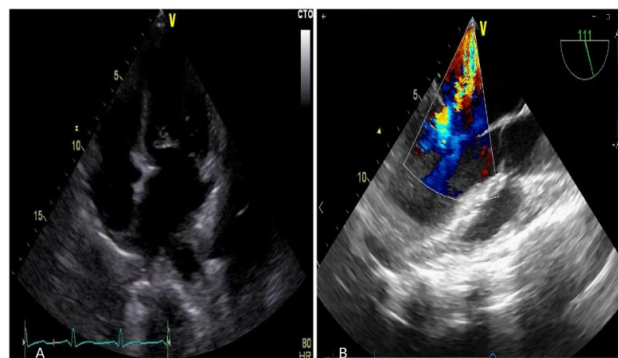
(A) Control transthoracic echocardiography showed empty cavum of the left atrium, without tumor mass in left atrium. (B) Control transesophageal echocardiography showed severe mitral regurgitation based on prolapse of the anterior mitral leaflet.
